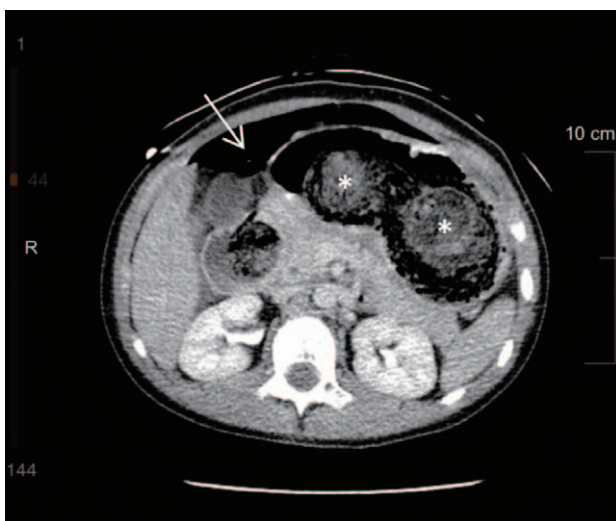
Axial computed tomography scan showing a large amount of material in the stomach (asterisks) with a significant amount of free air detected in the peritoneum (arrow).
